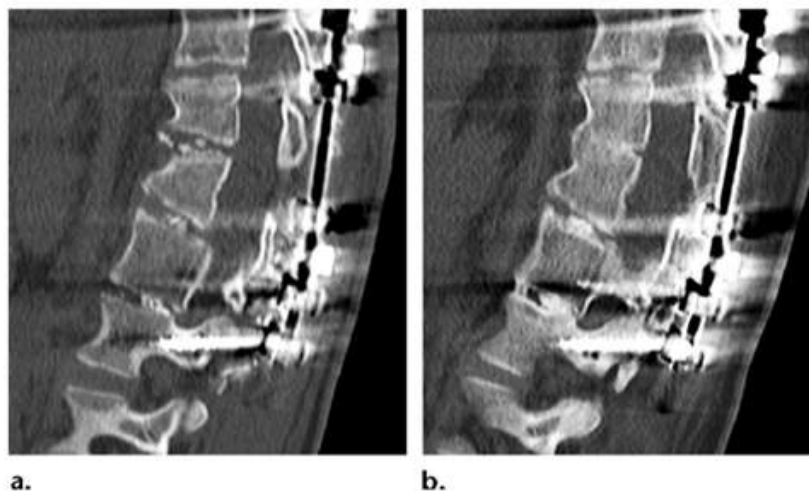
Two CT examinations (1-year interval) after placement of a metallic device for idiopathic scoliosis in a boy. Sagittal CT images acquired at 120 kVp (CTDI Vol was 8.1 mGy) when the boy was 12 years old (a) and at 100 kVp when he was 13 years old (5.7 mGy) (b) show that artifacts from the metallic device are significantly accentuated on the 100-kVp image.
